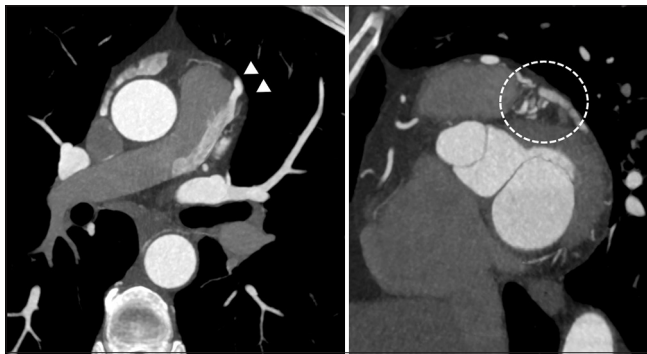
Maximum intensity projection reconstructions of the coronary computed tomography angiography show the site of fistula to main pulmonary artery (white arrowheads) and multiple fistulous vessels around the left anterior descending artery (dashed circle).
